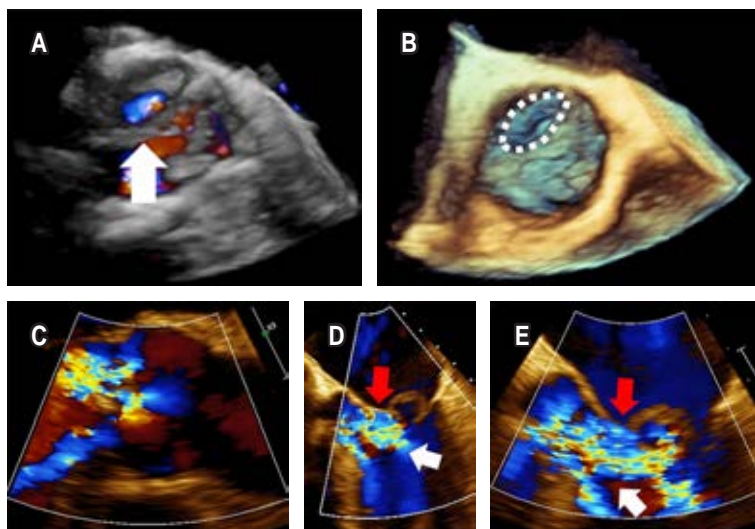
Transesophageal echocardiography: A) 3D image with color Doppler showing flow on the non-coronary cusp of the aortic valve (white arrow), B) 3D image with discontinuity of non-coronary cusp (white dotted line mark), C) 2D image with color Doppler at 125° showing lateral and central jets of aortic regurgitation, D, E) 2D image with Color Doppler at 45° showing the aortic regurgitation jet (white arrow) impinging on the anterior mitral leaflet (red arrow).
